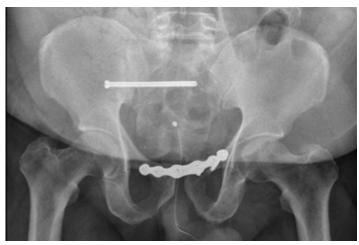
X-ray pelvis (Postoperative image)
